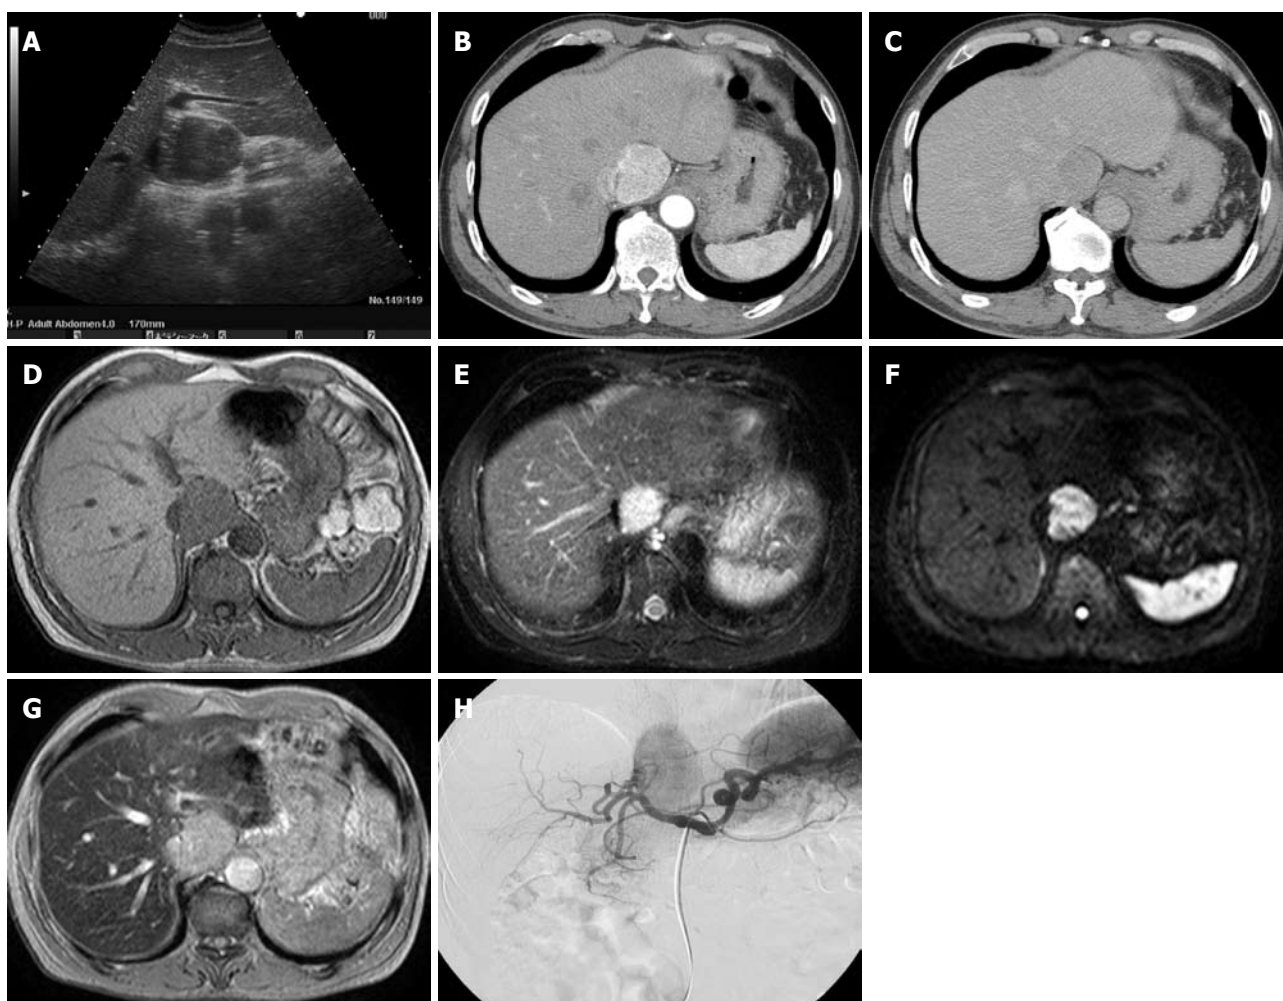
Images. A: The tumor was hypoechoic on ultrasonography, measuring 4.2 cm \times 4.0 cm; B-C: Enhanced computed tomography showed a tumor with early-phase hyperattenuation and late-phase hypoattenuation; D-F: Magnetic resonance imaging showed a tumor with hypointensity on T1-weighted, hyperintensity on T2-weighted images and hyperintensity on diffusion weighted images; G: The tumor did not absorb iron on superparamagnetic iron oxide-enhanced MRI; H: On angiography, the tumor was shown as a circumscribed hypervascular mass.
